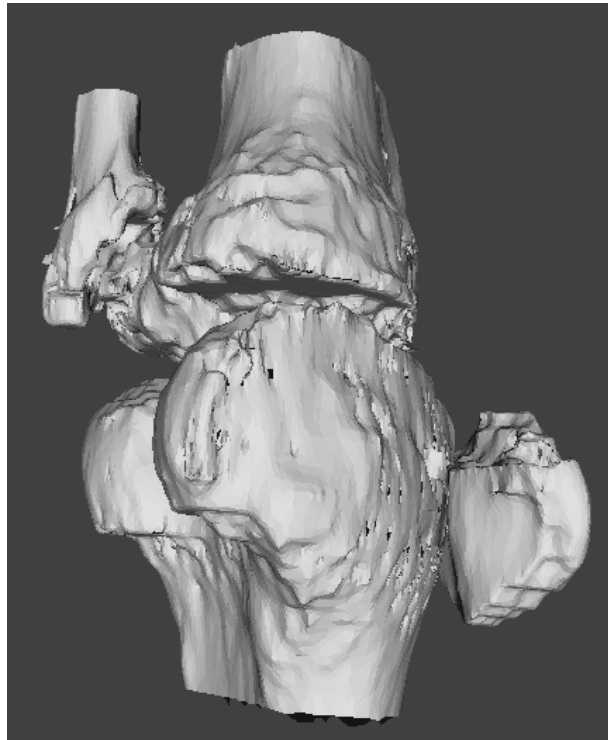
A 3D model of the knee joint generated from a classified CT dataset.
